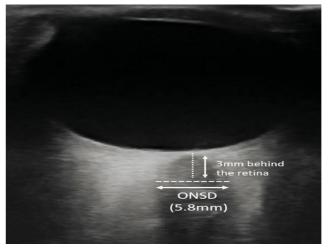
Optic nerve sheath diameter (ONSD) measurement using transorbital ultrasound
